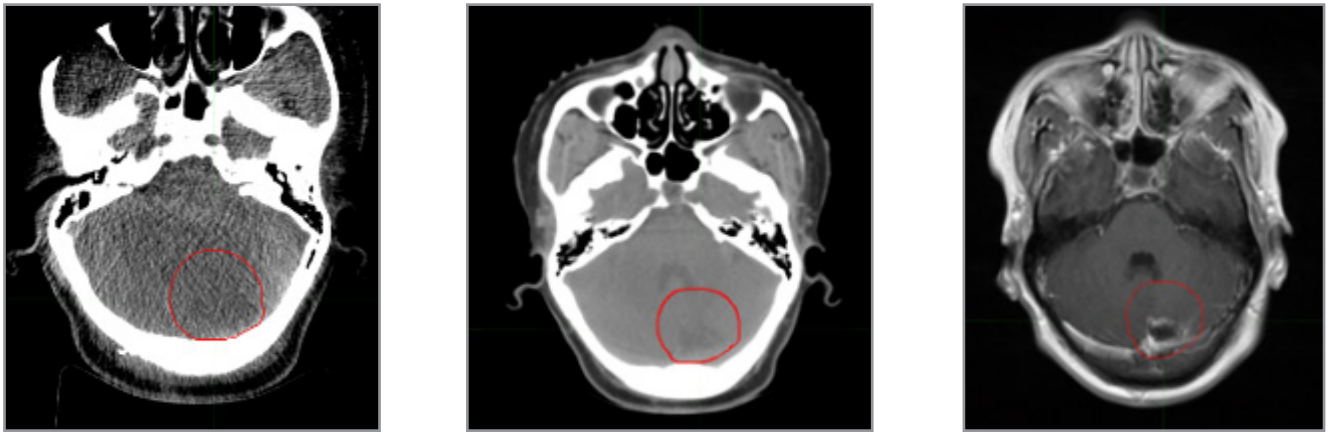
From left to right CBCT image, CT image and MR images attained by corresponding machines.
